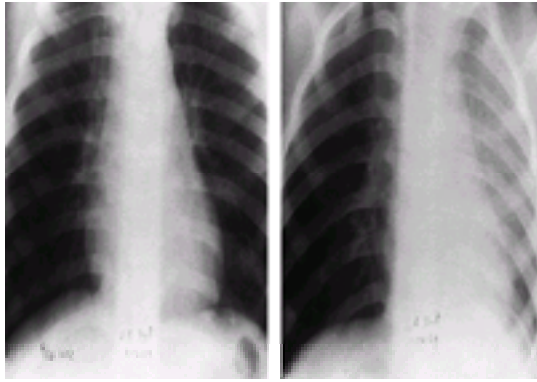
Inspiratory and expiratory chest radiographs demonstrating air trapping in the right lung during expiration, indicating likely right-sided foreign body. A peanut was removed at bronchoscopy.
